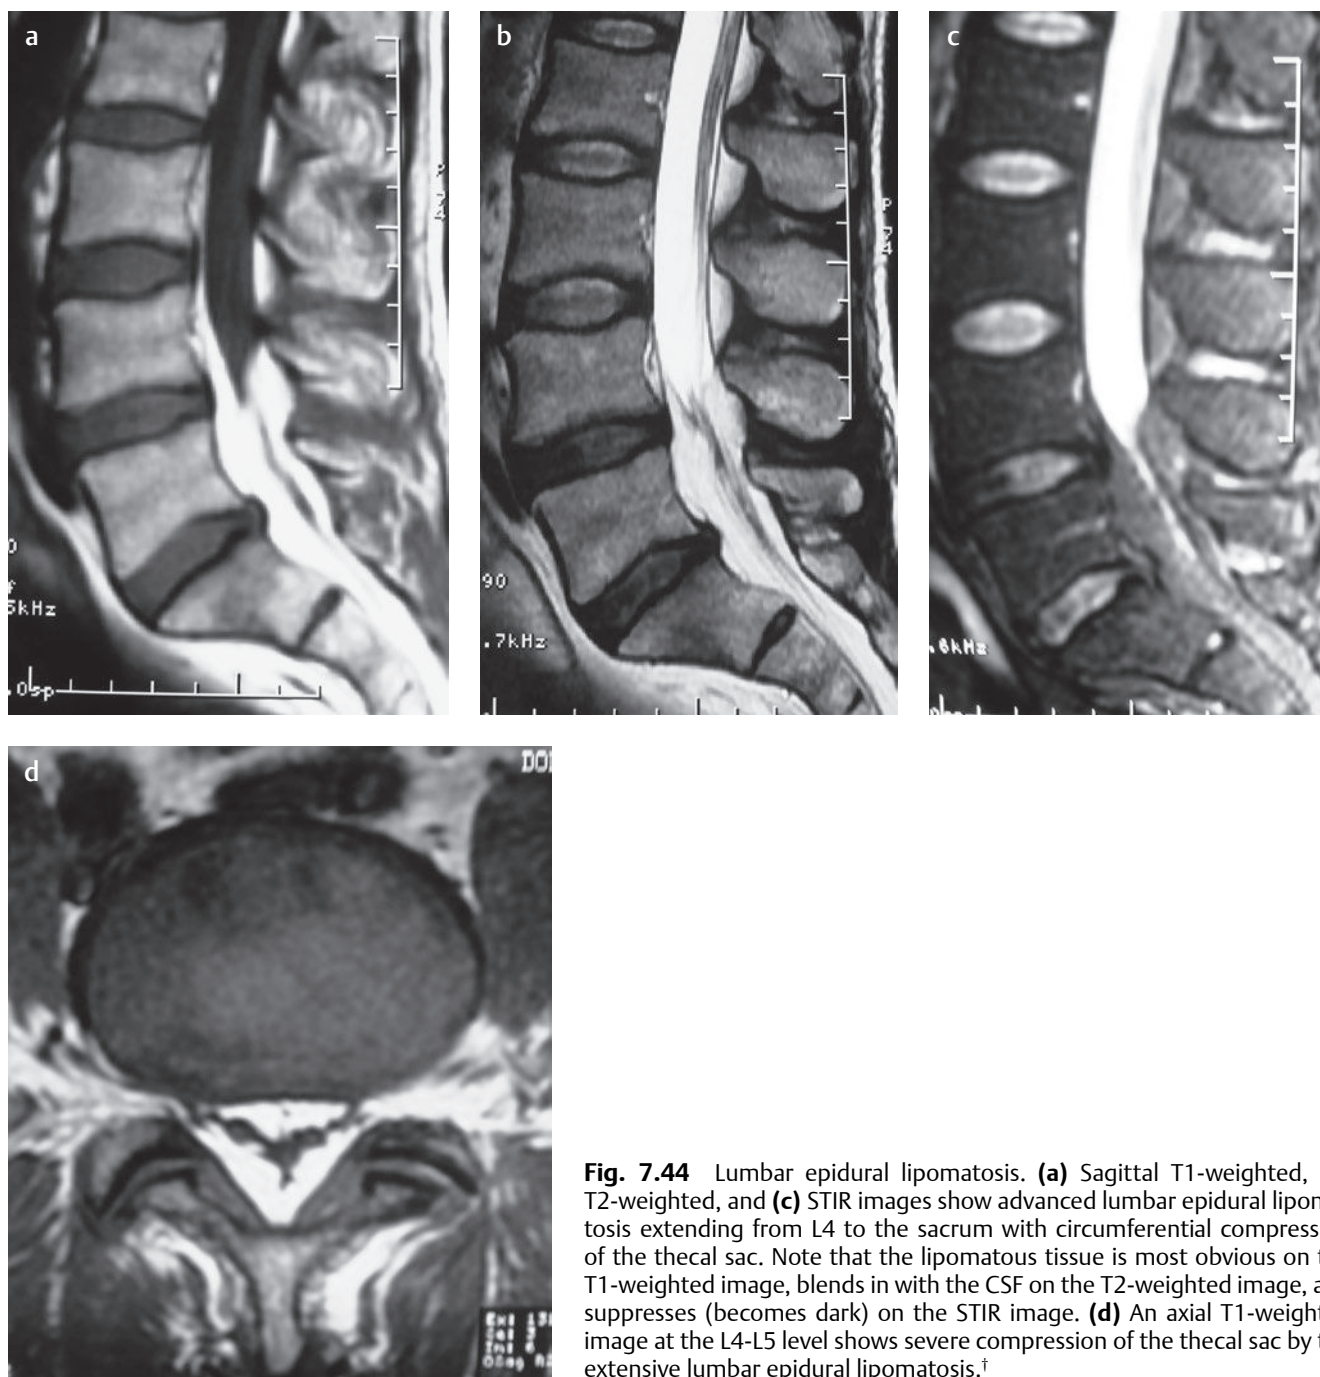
Lumbar epidural lipomatosis. (a) Sagittal T1-weighted, (b) T2-weighted, and (c) STIR images show advanced lumbar epidural lipomatosis extending from L4 to the sacrum with circumferential compression of the thecal sac. Note that the lipomatous tissue is most obvious on the T1-weighted image, blends in with the CSF on the T2-weighted image, and suppresses (becomes dark) on the STIR image. (d) An axial T1-weighted image at the L4-L5 level shows severe compression of the thecal sac by the extensive lumbar epidural lipomatosis.[†]
